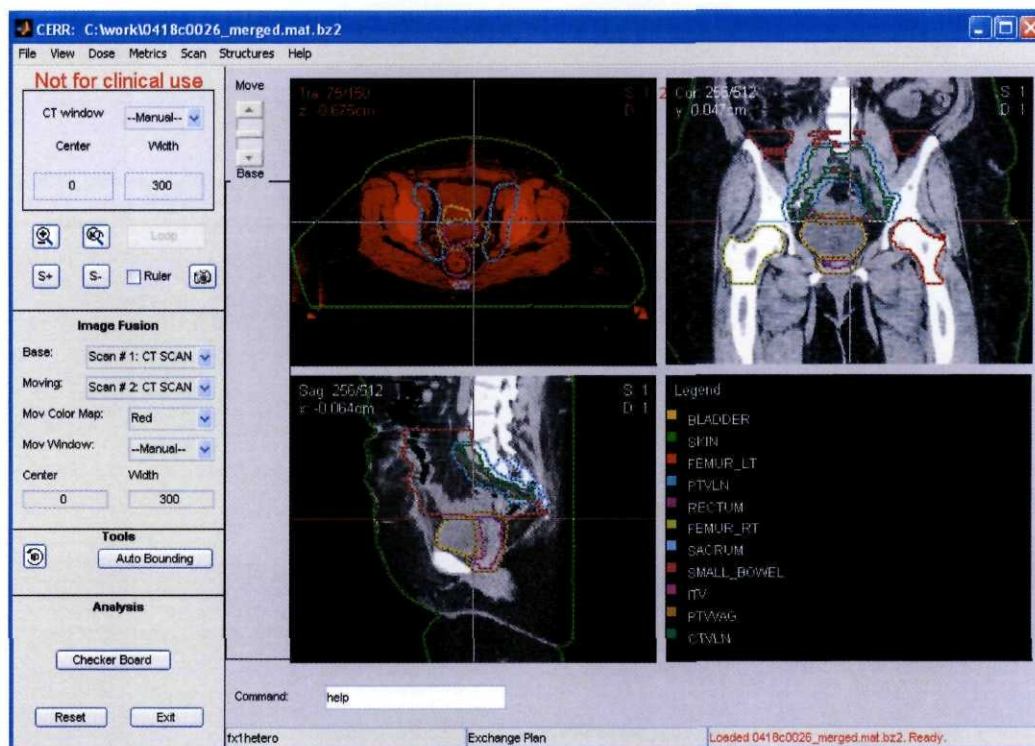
CERR display being used to support RTOG GYN trial having specialized needs: (a) requires review of contours from two different fused CT imaging studies one with bladder full and one with bladder empty; (b) and the need to review submissions simultaneously by two PIs at different locations.
